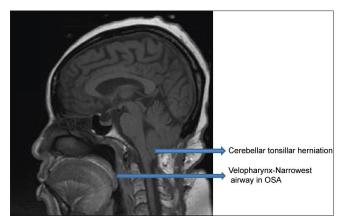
MRI scan showing cerebellar tonsillar herniation of 17 mm below foramen magnum
